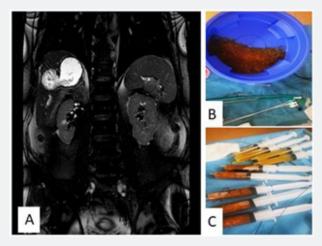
MRI of the abdomen [A]; Cystic content [B]; The initial aspirate forwarded for cytological and biochemical and microbiological analyses [C].
